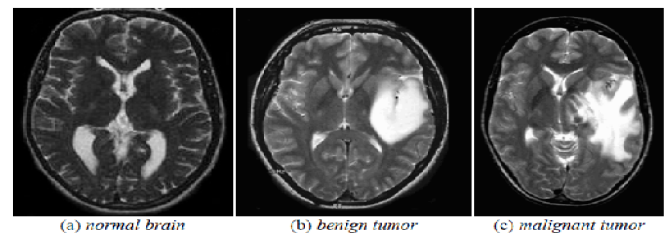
Three T2 weighted MR images in axial plane (a) Normal brain (b) benign tumour (c) malignant tumour
